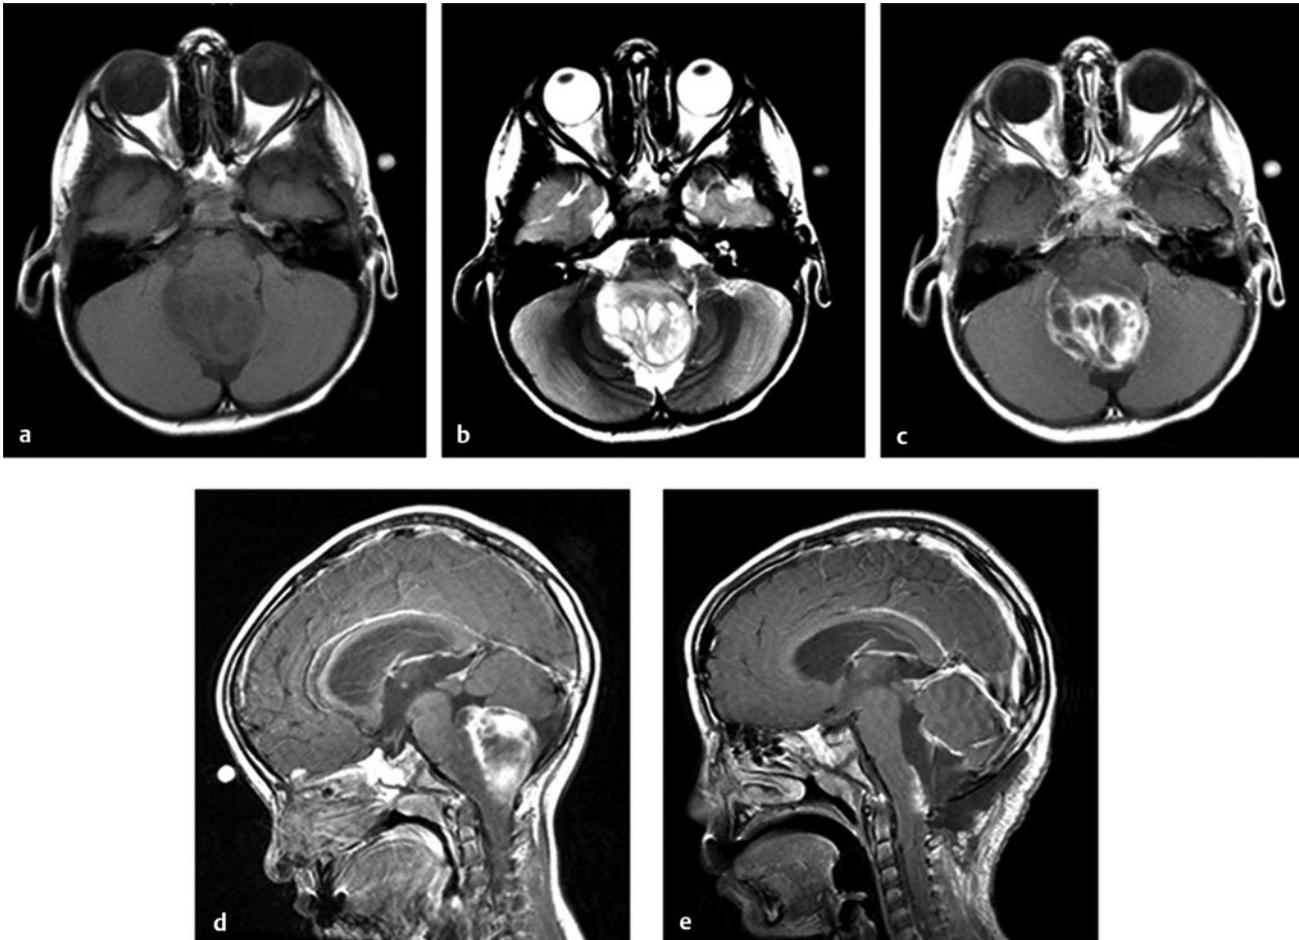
Dorsal exophytic brainstem tumor. (a) Axial T1-weighted magnetic resonance (MR) image of a child with a dorsal exophytic brainstem tumor demonstrating dorsal extension of the tumor. (b) Axial T2-weighted MR image of the same patient. (c) Axial and (d) sagittal T1-weighted MR images with gadolinium contrast demonstrating contrast enhancement, as is typical of this type of tumor. (e) Sagittal T1-weighted MR image with gadolinium contrast of the same patient after resection. Most of the exophytic tumor could be resected. However, these tumors typically have a poorly demarcated interface with the brainstem, so that a small amount of tumor must be left to prevent injury to the brainstem. Note the area of contrast enhancement representing residual tumor on the dorsal surface of the brainstem.
